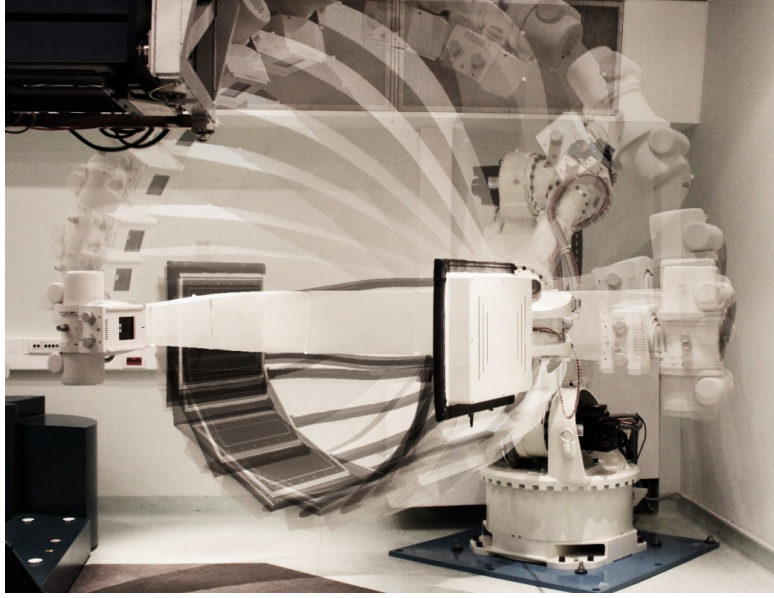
Short time-lapse depicting conventional motion of custom in-room CBCT imaging system at CNAO. On the bottom left, one can observe the base of the robotic couch, which prevents the full rotation of the C-arm.
